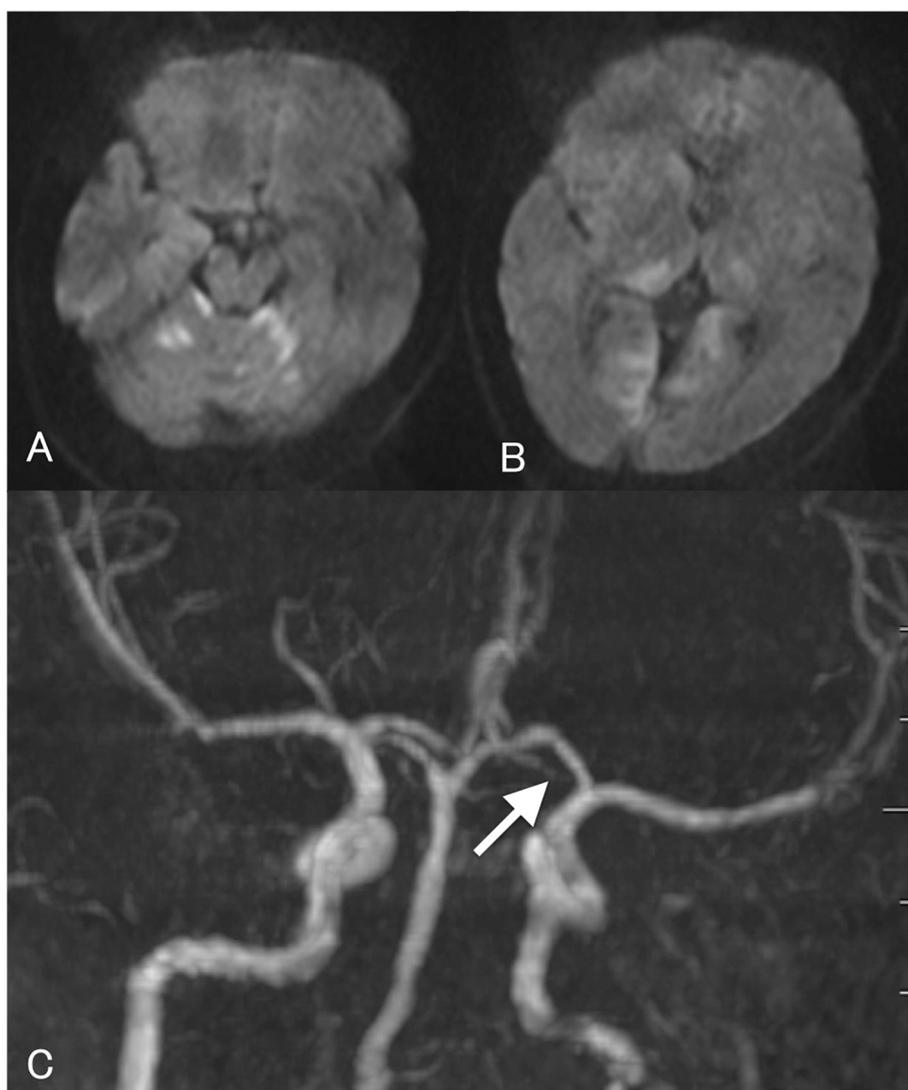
Magnetic resonance imaging on admission. A, B: Initial magnetic resonance diffusion-weighted imaging shows a slightly high-intensity area in both sides of the occipital lobe, thalamus, cerebellum, midbrain, and pons. C: Magnetic resonance angiography shows left posterior cerebral artery occlusion (arrow).
